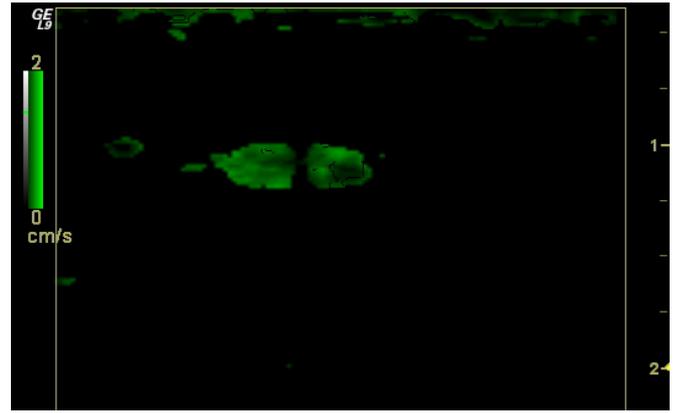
A variance Doppler image of the stationary acoustic field generated by two focused 1 MHz transducers at a depth of 7 cm. The units of the labels on the right-hand side are centimeters. Notice that the size of the focal region is less than 0.5 cm x 0.3 cm. The intensity units are relative.
